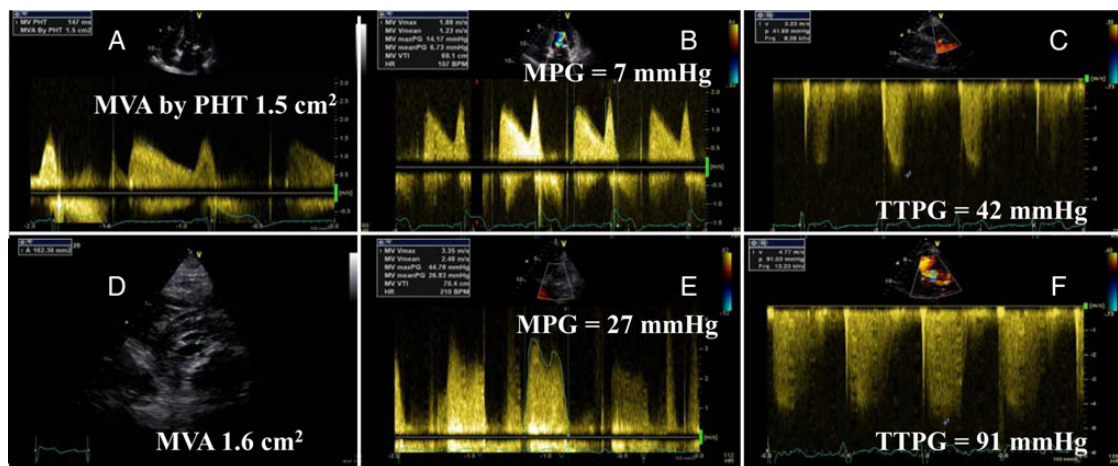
Patient with moderate mitral stenosis (mitral valve area (MVA) measured by pressure half time (PHT) (A) and planimetry methods (D)) and dyspnoea. With exercise, there was a significant increase in systolic PAP (transtricuspid pressure gradient (TTPG)) (D) and in transmitral pressure gradient (MPG) (E), indicating haemodynamically significant mitral stenosis. (A–D) Rest evaluation; (E and F) exercise echocardiography results.
